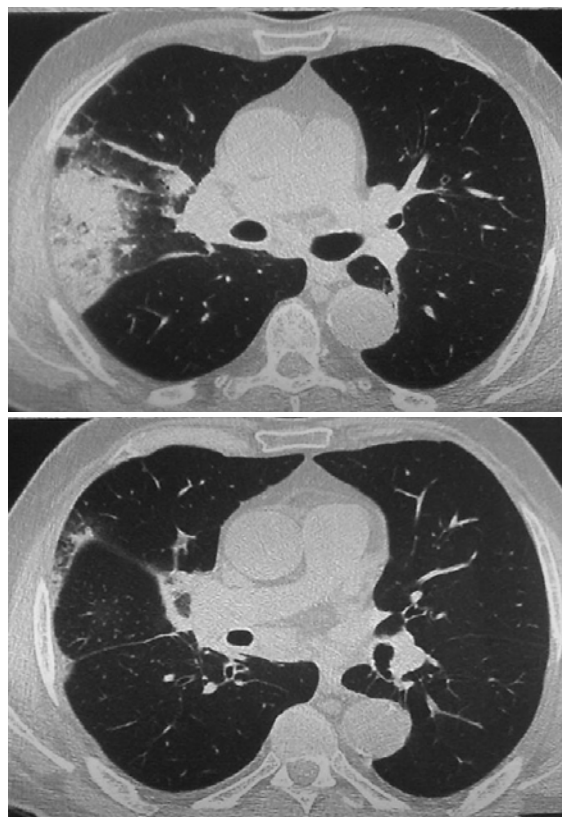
Computed tomography showed lobar infiltration in right upper lobe.
